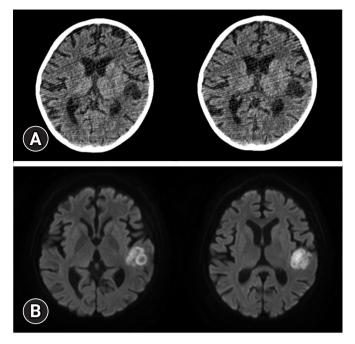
Radiological imaging of the brain. (A) Initial brain computed tomography (CT) of the patient showed an approximately 2.3 cm low-density lesion in the left temporoparietal lobe. This lesion presented the possibility of a cystic lesion or low-density mass, such as cystic encephalomalacia. (B) Brain magnetic resonance imaging of the patient after Brain CT. It showed an approximately 2.7 cm rim-enhancing mass with diffusion restriction in the left superior temporal gyrus, suggesting a brain abscess.
